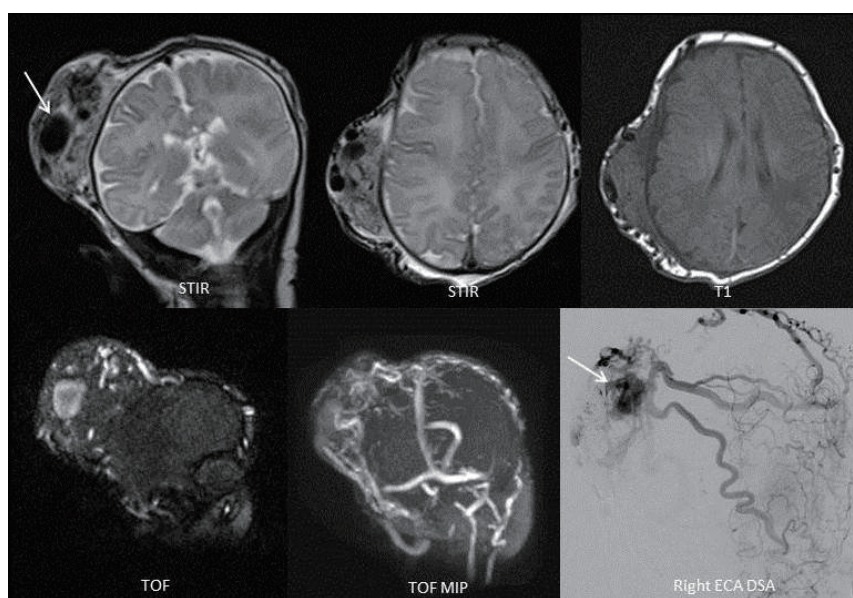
MRI and right external carotid injection DSA demonstrating kaposiform hemangioendothelioma. MRI, magnetic resonance imaging; DSA, digital subtraction angiography.
